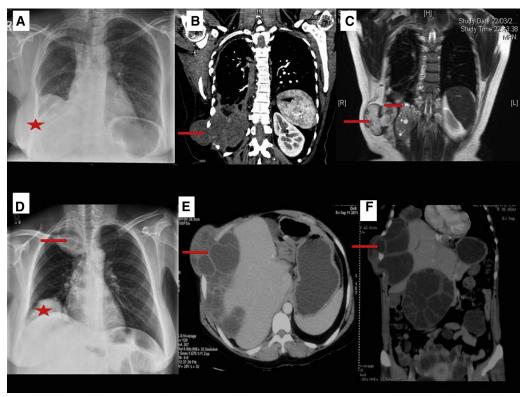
A, Chest x-ray showing the hydatid cyst in the right lower zone, projecting outside the chest wall (*star*). B, Contrast-enhanced computed tomography of the thorax, coronal view, showing primary pleural Hydatid cyst extending through the chest wall as hydatid necessitans (*arrow*). C, Magnetic resonance imaging of the thorax, coronal section, showing hydatid necessitans (*arrow*) and multiple hyperintense daughter cysts within the pleural hydatid cyst (*small arrow*). D, Chest x-ray showing hydatid cyst as well-defined opacities in the right lower (*star*) and upper zones (*arrow*). E, Contrast-enhanced computed tomography of the thorax, axial view, showing primary pleural hydatids extending out through the intercostal space (*arrow*). F, Contrast-enhanced computed tomography of the thorax, coronal view, showing the hydatid necessitans (*arrow*) along with multiple intra-abdominal cysts.
